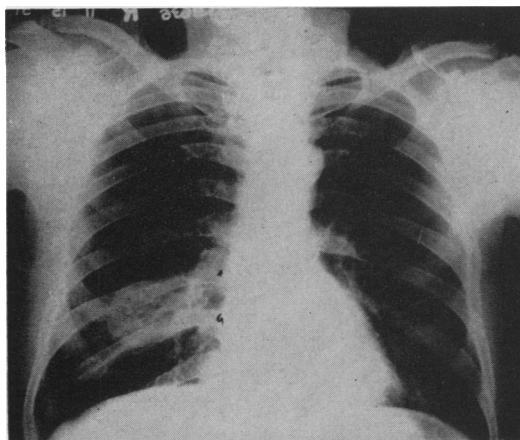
Roentgenogram of chest revealing a mass in the chest opposite the eighth and ninth ribs posteriorly.
